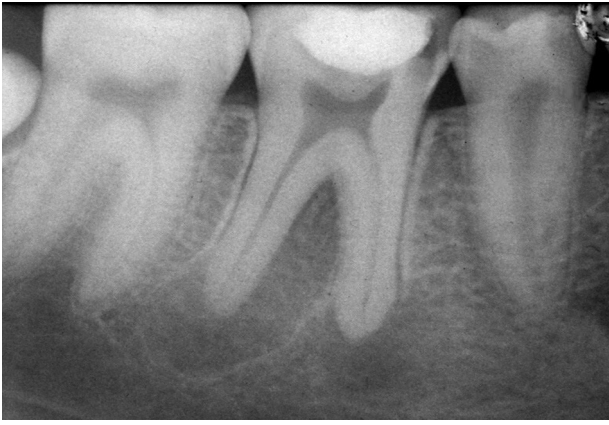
Preoperative radiograph of 4.6, there is a big periapical lesion of the distal and mesial root.
